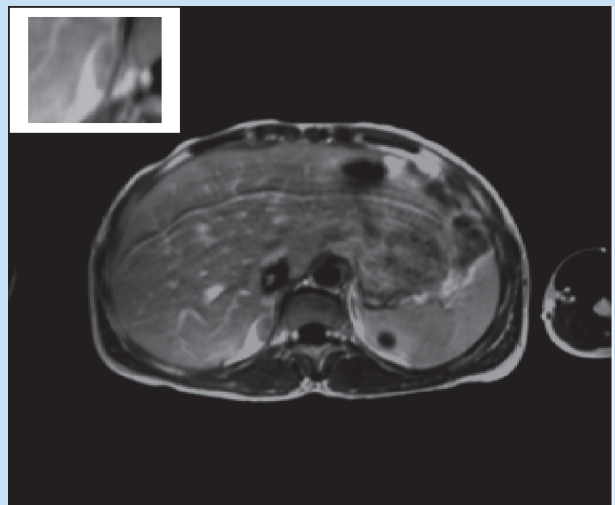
The post-gadolinium T1 weighted (TR 525/TE 13) axial MRI demonstrates contrast enhancement of the mass easily visualised in the right adrenal gland. There is an incidental simple cyst in the left kidney. The left adrenal gland is well demonstrated and is normal.
